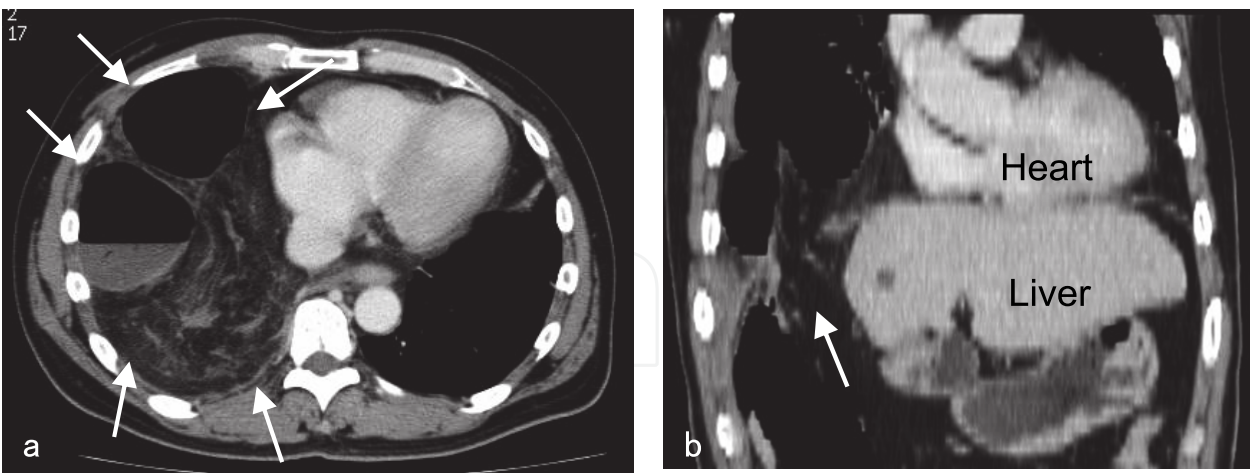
Computed tomography scan obtained at the hospital emergency department twenty months later after the radiofrequency ablation therapy. (adapted from Nawa T et al).
